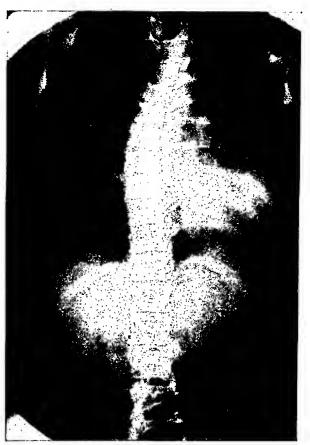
Case I. Roentgenogram of spine showing scoliosis.
